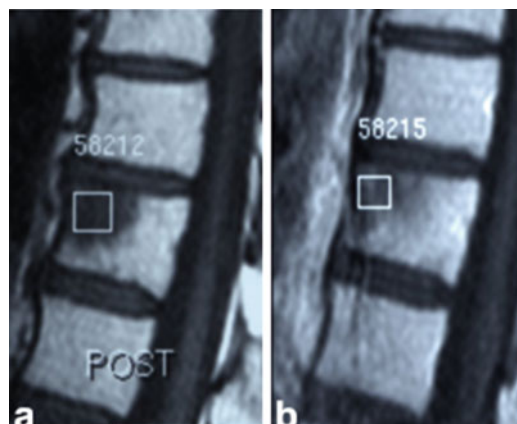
Sagittal T1TSE MRI images of the same patient 3 months post the onset of treatment. The signal intensity before Gd enhancement (Fig. 21.4a) was lower than that the corresponding value before treatment (Fig. 21.3a). After Gd administration the difference in enhancement between the images before (Fig. 21.3b) and after treatment (Fig. 21.4b) was not as high as in the case before treatment (Fig. 21.3a vs b) (This figure is reprinted from the book *Bone Metastases: A translational and clinical approach*, chapter 17: Assessment of therapeutic response pages 344–370, figure 17.4, copyright 2009, after a kind permission of Springer Science and Business Media B.V.)
